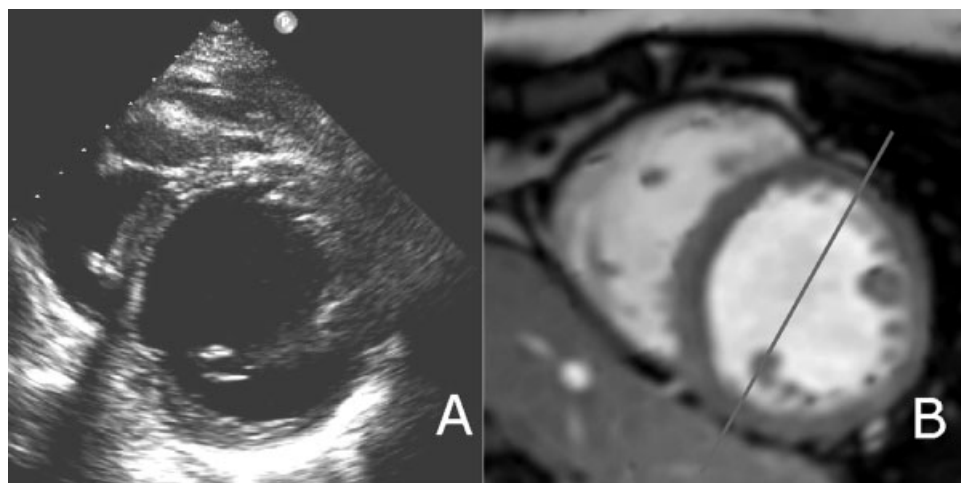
An echocardiographic short axis view (A) is in its usual display position, and (B) is a magnetic resonance image seen in short axis and rotated to the same
